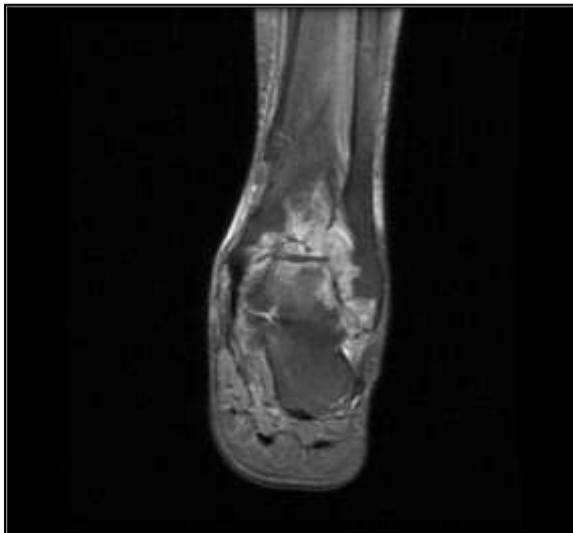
Coronal proton density fat-saturated (PD-FS) MRI of the ankle demonstrating features of tubercular arthritis.
